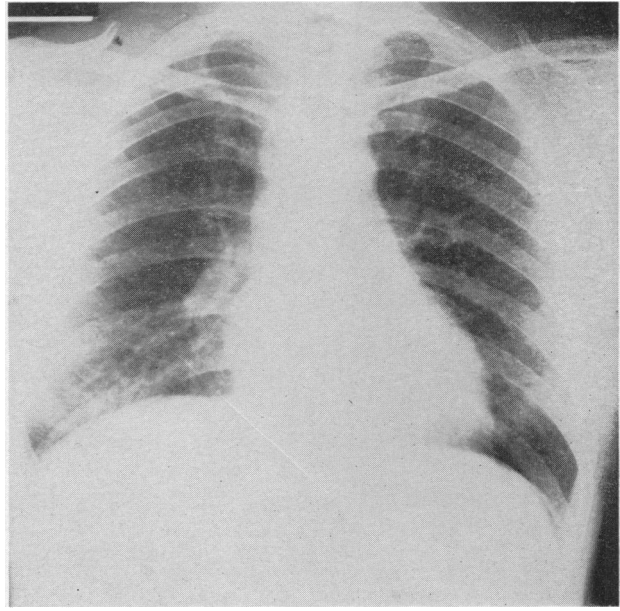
Case 2. Radiograph of chest, December, 1959, after four months' treatment with prednisone.
